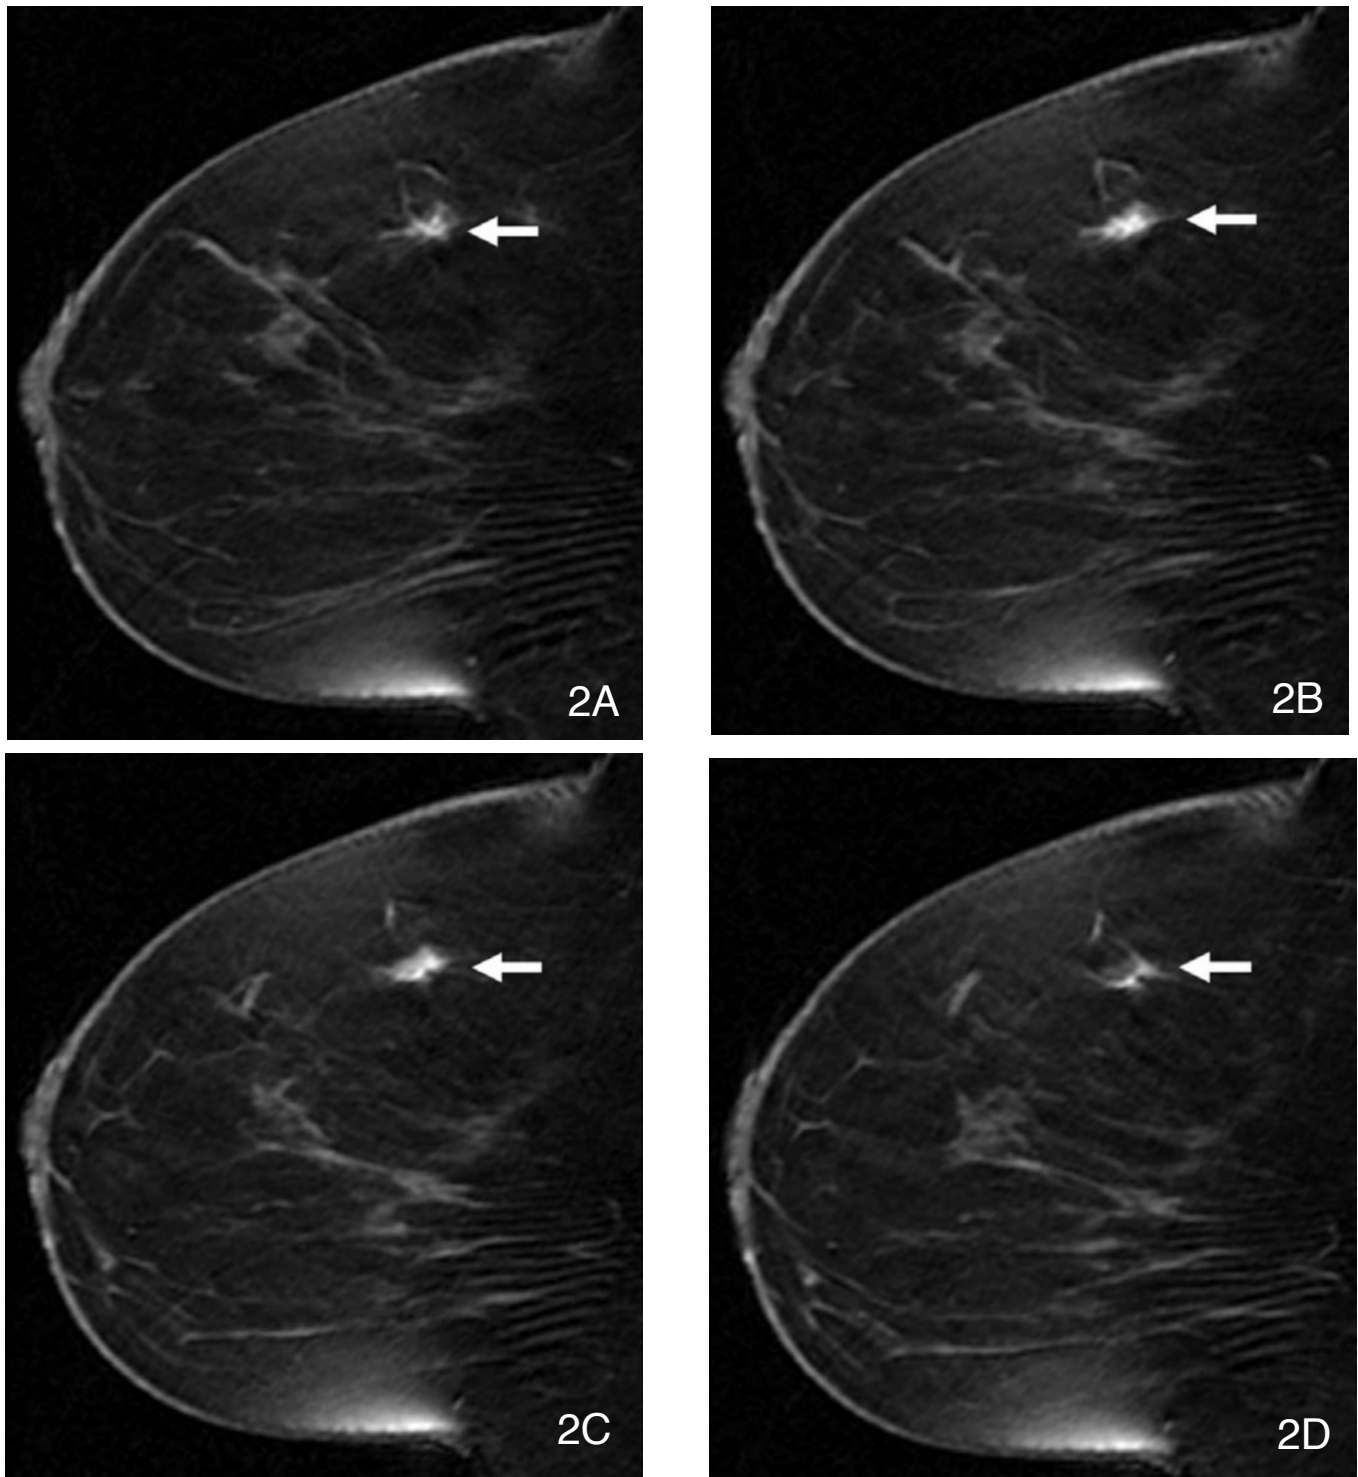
(A-D). Four sequential frames with 2 mm slice thickness from three dimensional fat suppressed T1-weighted gradient recalled echo sequence (from just medial to the nipple proceeding medially) obtained approximately 9 minutes after Gd-DTPA contrast injection demonstrate a spiculated mass in the left upper slightly inner breast (arrow).
